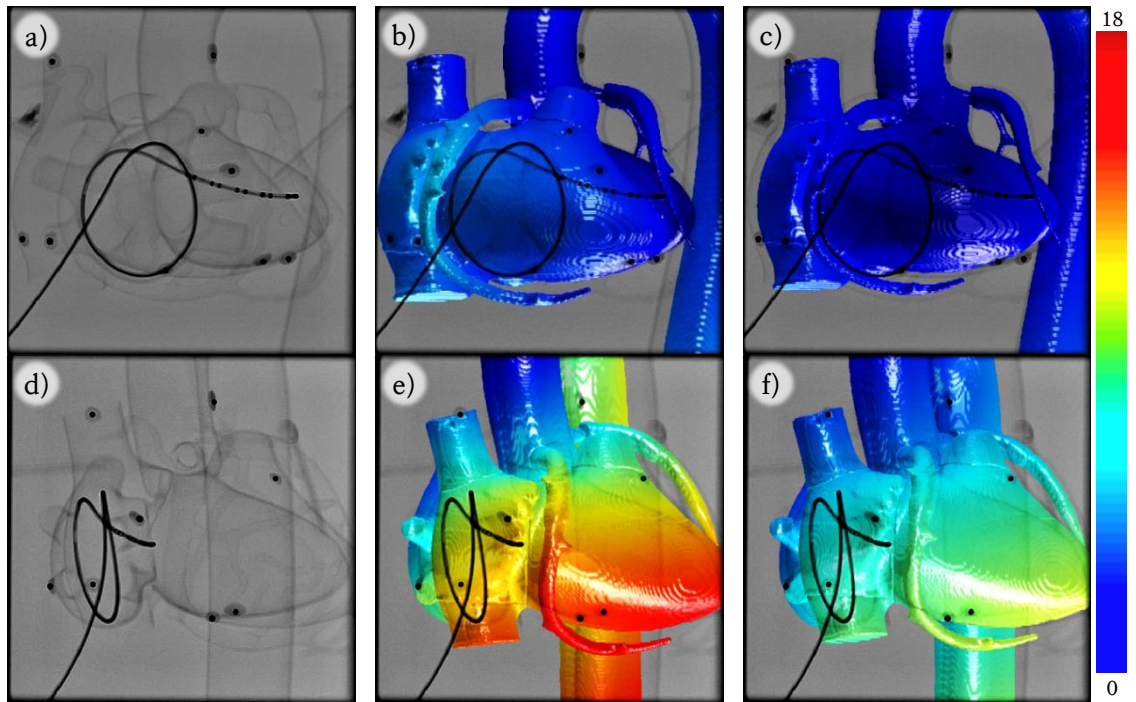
Visual representation of registration results using the b, e) monoplane 1×BNHC strategy and c, f) monoplane 2×BNHC strategy applied to the first looped catheter configuration. Colour mapping of the CT data surface rendering shows the spatial distribution of RPD. The data is overlaid onto X-ray in a, b, c) PA and d, e, f) RAO 45° views.
